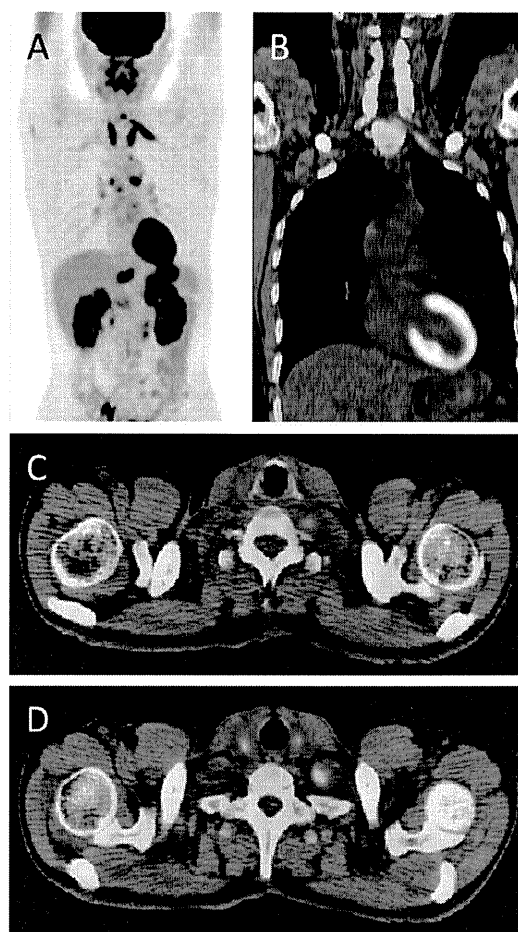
FDG-PET coronal maximum intensity projection image showed left C6 nerve involvement in addition to hepatic and renal accumulation (A). This nerve lesion was confirmed anatomically using PET/CT scans (B-D).
